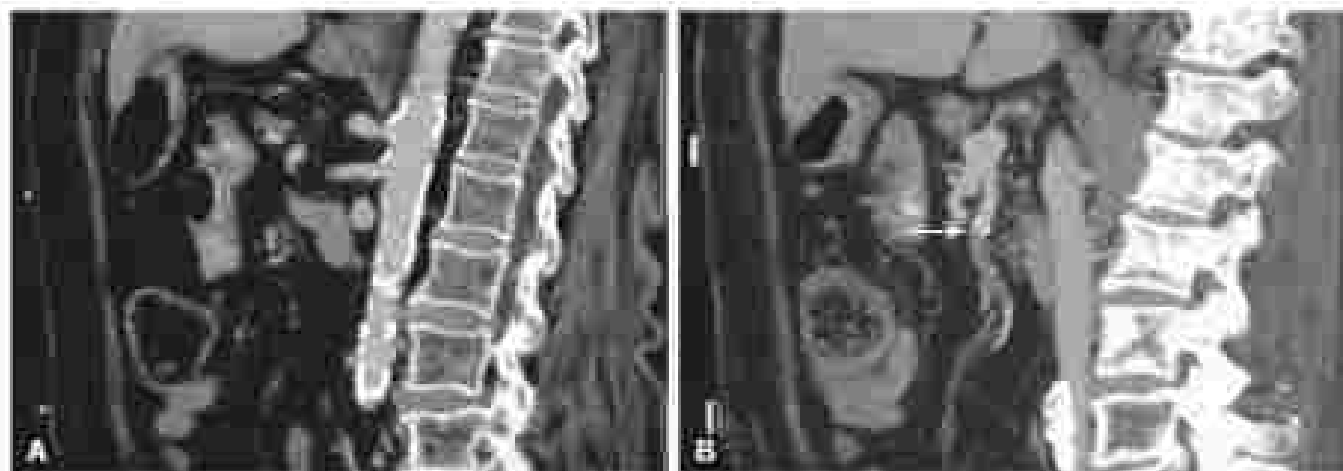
Thrombus in the superior mesenteric artery (SMA) demonstrated on computed tomography (A) Patient has dilated aorta and SMA origin. (B) Thrombotic non-SMA just distal to abdominal aortic plaque (arrow).
